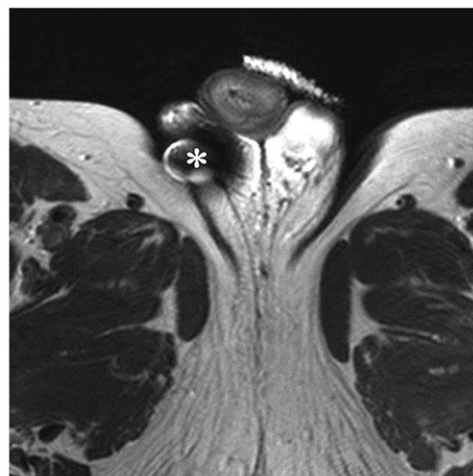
Artificial urinary sphincter in an 82-year-old man. T2-weighted sagittal right lateral (a) and axial (b, c) MR images through the pelvis show appropriate positioning of an artificial urinary sphincter in a patient with severe urinary incontinence that was refractory to medical management. The artificial urinary sphincter consists of a pressurized reservoir (arrow in a) in the abdomen, a sphincter cuff that goes around the bulbous urethra (arrowhead in b), and a pump placed in the scrotum (*). The pump in the right scrotum is partially obscured by susceptibility artifact.
